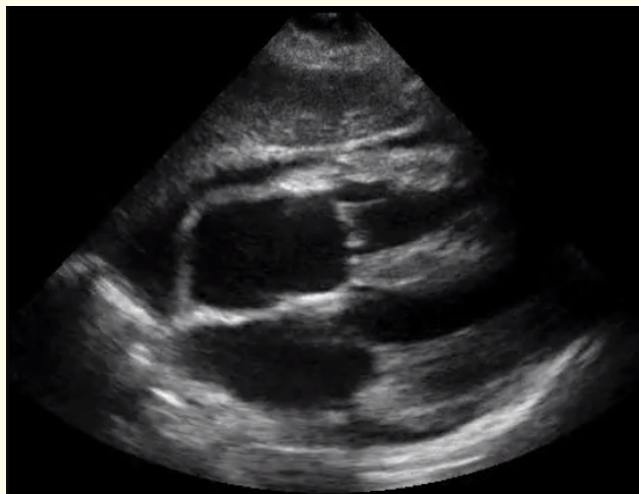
Apical 4 chamber view showing features of cardiac tamponade.
